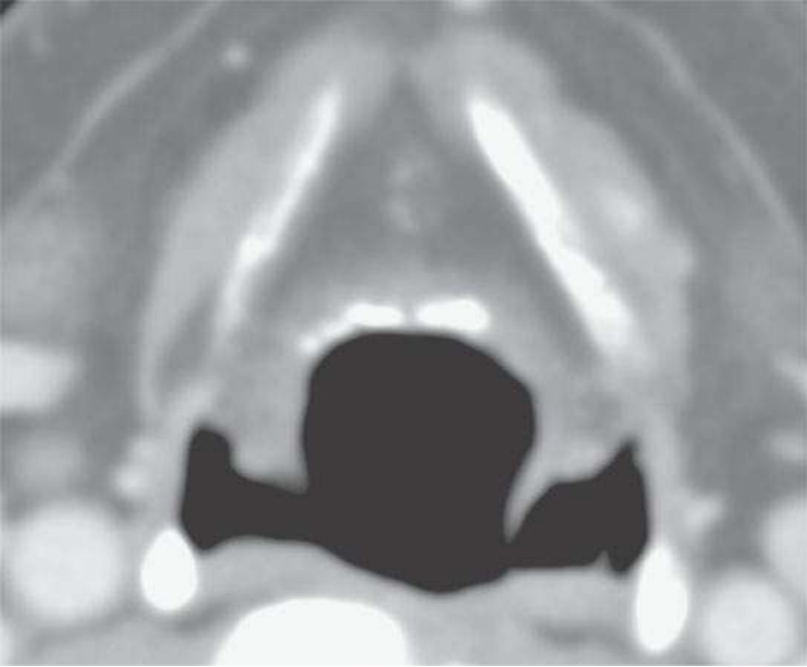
Computed tomography of "physiologic" calcification of the infrahyoid epiglottis. This is inconsequential.
